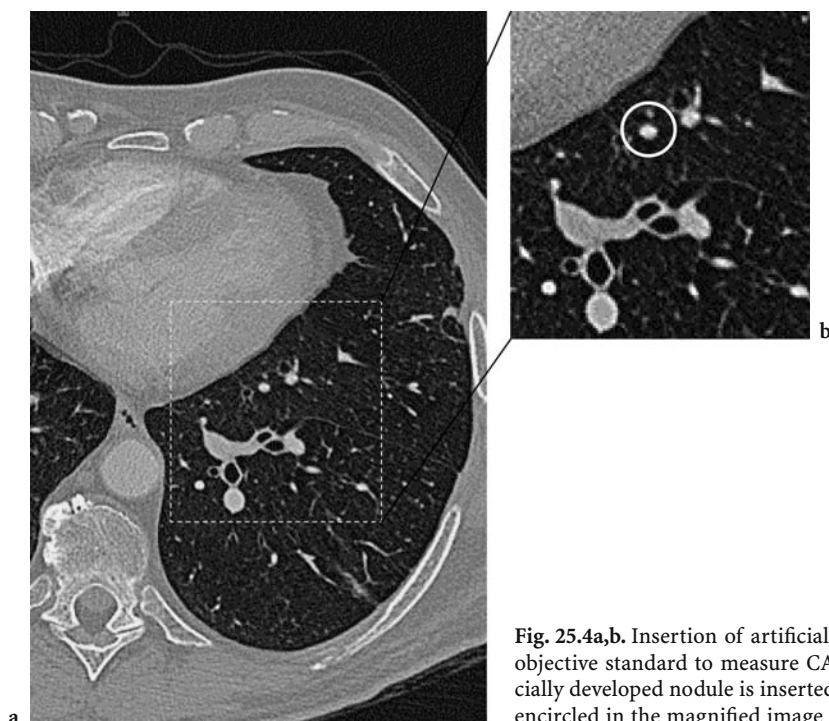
Insertion of artificial nodules is a possible way to develop an objective standard to measure CAD stand-alone performance. The artificially developed nodule is inserted into the original CT image (a) in shown encircled in the magnified image (b).
